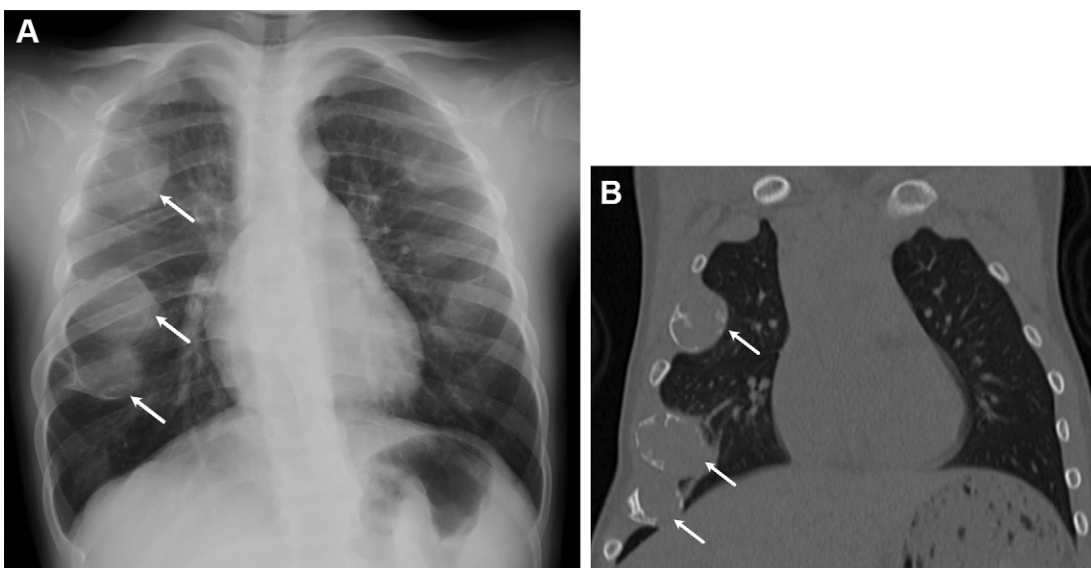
Multiple enchondromas (Ollier disease) in a 4-year-old girl. (A) Frontal chest radiograph shows multiple well-defined expansile lucent lesions at the costochondral junction with the largest lesions at the right third, fifth, and sixth ribs (arrows). (B) Coronal CT image of the chest shows multilobulated expansile intraosseous lesions with endosteal scalloping and cortical thinning (arrows) consistent with enchondromas. There is no soft-tissue mass or periosteal reaction.
